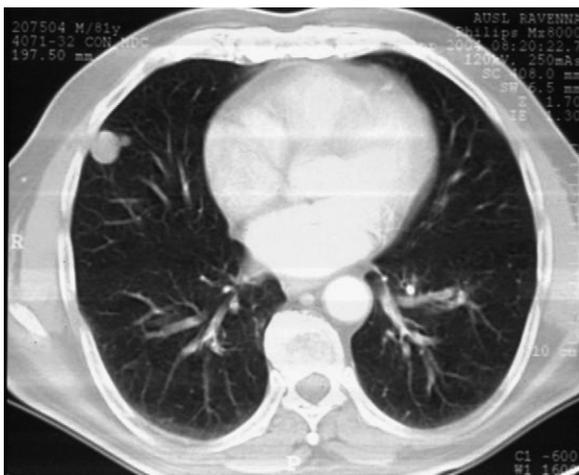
CT showing a pulmonary nodule of 1.5 cm in the subpleural parenchyma of the right middle lobe, with sharp outlines and a rounded small protuberance.
